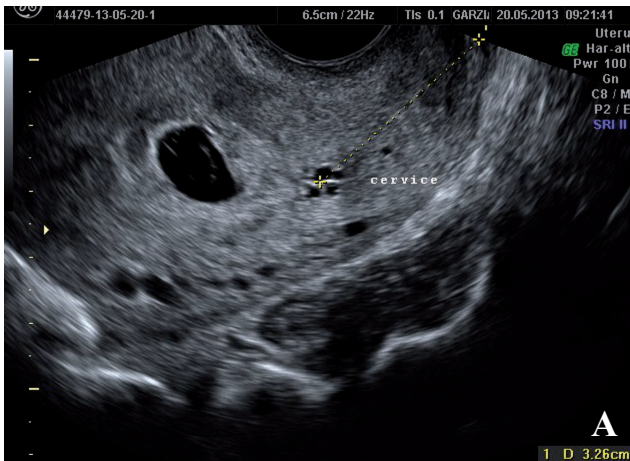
Gray scale ultrasound (Figure 2A) and hysteroscopic findings (Figure 2B) of patient 7 are shown. Both ultrasound imaging and hysteroscopy show a placental implantation involving the cesarean scar, but a prevalent cranial placental growth towards isthmus and endometrial cavity is shown, consistent with a type 1 CSP.
